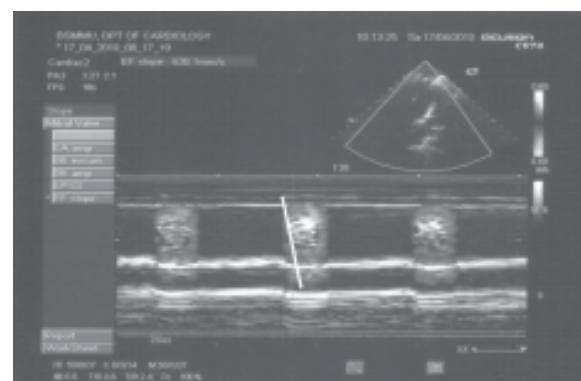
Color M-Mode Doppler Echo shows AVP 62.8 cm/sec.
